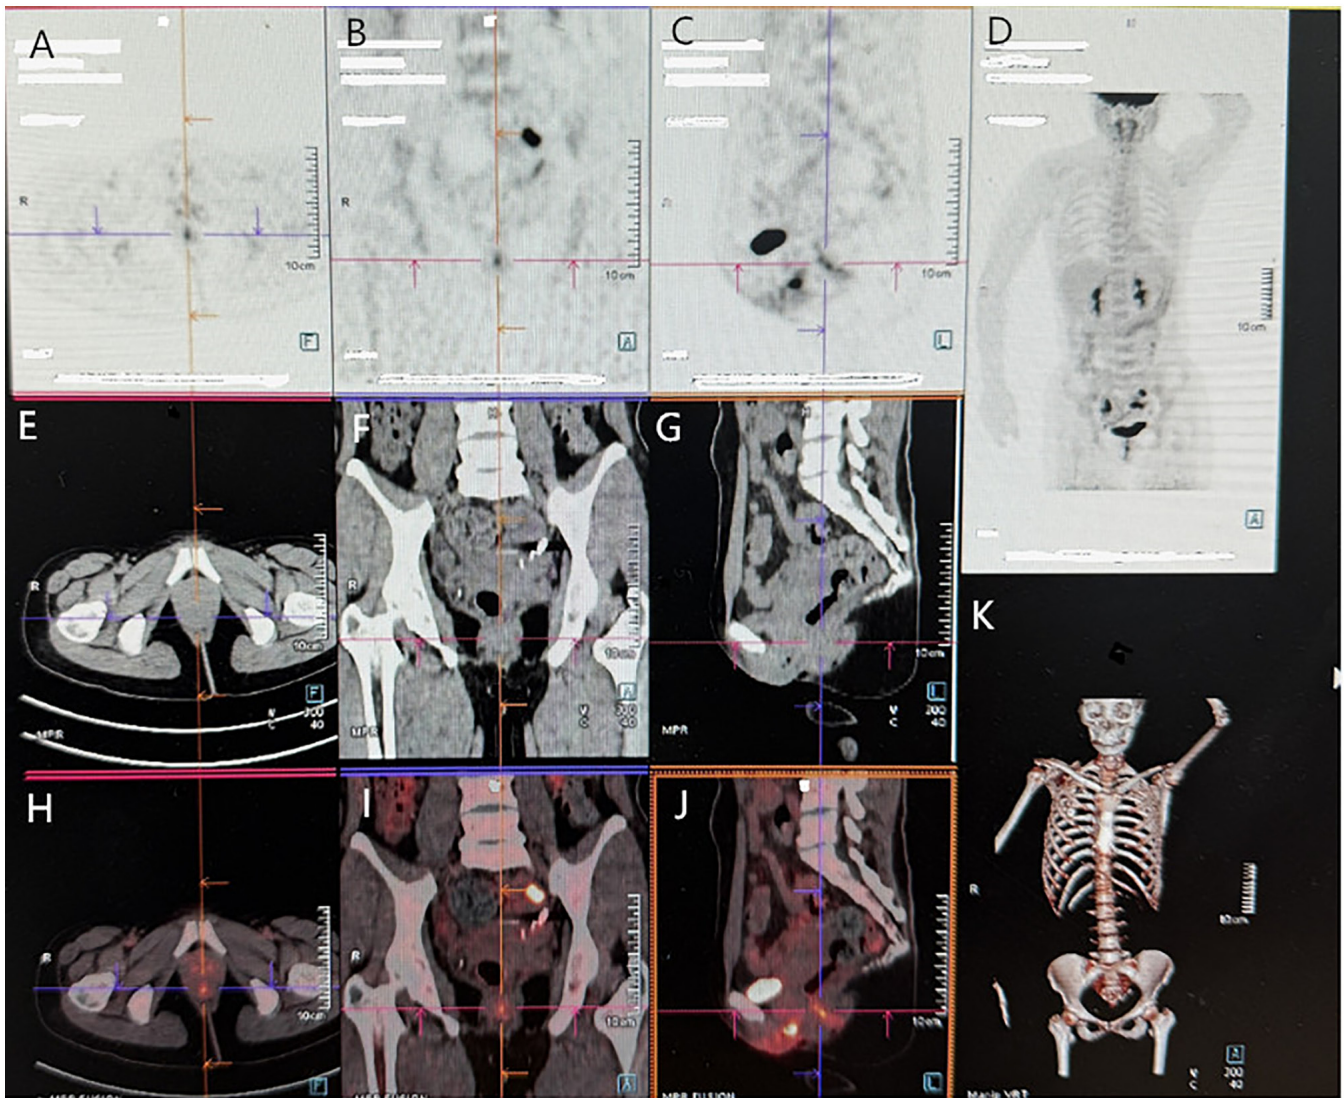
Positron emission tomography-CT examination did not find any residual tumor in the anal canal and para-rectum, lymph node enlargement or metastasis. (A) Transverse PET: No large abnormal concentrations in the pelvis. (B) Coronal PET: A single hypermetabolic black spot in the middle and lower pelvic cavity. (C) Sagittal PET: Well-defined, hyperdense foci in the pelvic cavity anterior to the sacrum. (D) Whole body reconstruction PET panorama: No abnormal concentration in the head, neck, chest and bones, and a small number of hypermetabolic spots in the pelvis. (E) Transverse CT: Pelvic bone integrity without destruction, pelvic soft tissue space was clear, and small nodular soft tissue shadow was seen in the corresponding area of metabolism. (F) Coronal CT: Lumbosacral and pelvic bone intact, small soft tissue nodules in the middle of the pelvis matched with PET hypermetabolism location. (G) Sagittal CT: The bladder, rectum and sacrococcygeal layers could be distinguished, and the soft tissue thickening nodules between the bladder and rectum were corresponding to the PET abnormal lesions. (H) Transverse fusion map: Bright red hypermetabolic hot spots without bone accumulation in the pelvic soft tissue. (I) Coronal fusion map: Localized orange-red hypermetabolic nodules were seen in the pelvic cavity, and there was no hot spot of bone metastasis in the lumbosacral pelvis. (J) Sagittal fusion map: A large red hypermetabolic area was seen in the pelvic soft tissue, which could distinguish the lesion from the bladder, intestine and sacrum. (K) No lesions were found in the whole body skeleton 3D reconstructed skeleton.
